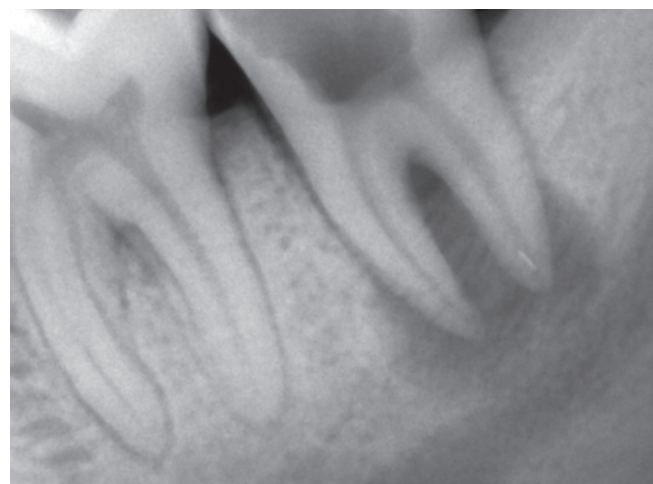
Preoperative radiograph (Case 1)
